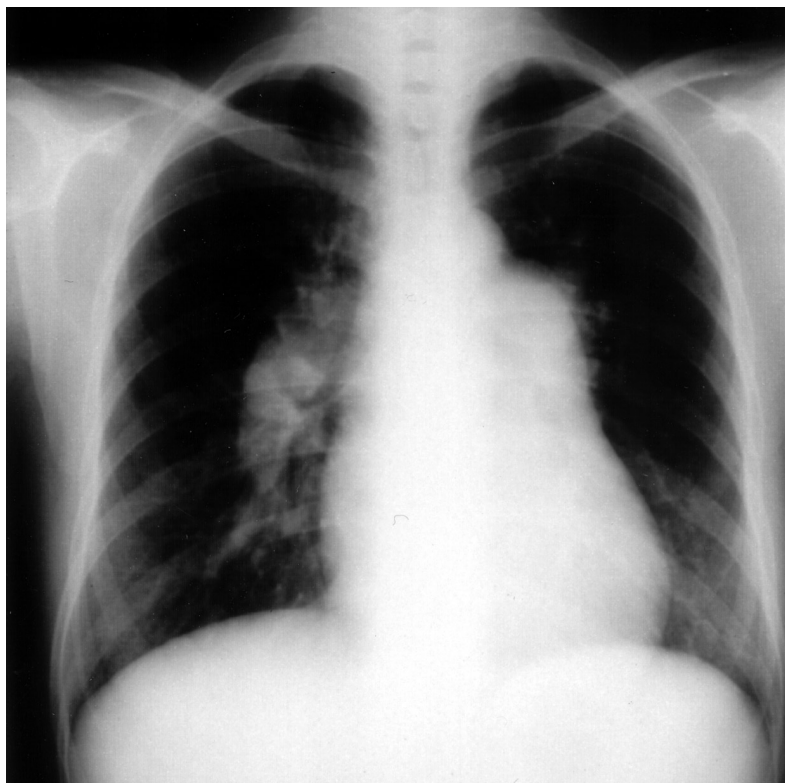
Chest radiograph at the diagnosis of pulmonary hypertension 25 years ago.
